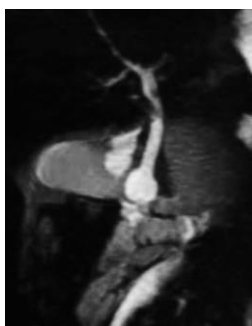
Lateral section of bile duct reconstruction using magnetic resonance imaging
